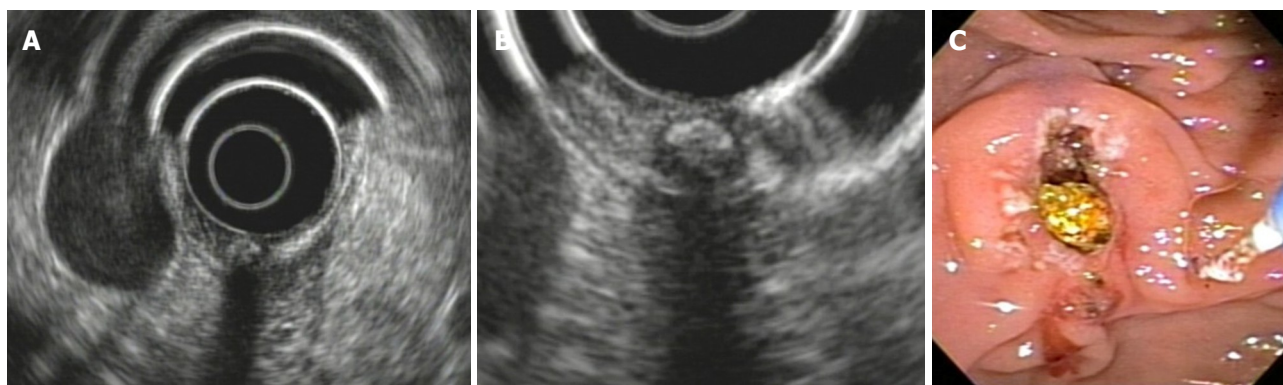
Endoscopic ultrasound finding in acute pancreatitis in a patient with normal magnetic resonance imaging. A: Impacted 4 mm stone in the ampulla with radial endoscopic ultrasound; B: Close-up; C: Precut during Endoscopic retrograde cholangiopancreatography in the same patient.
